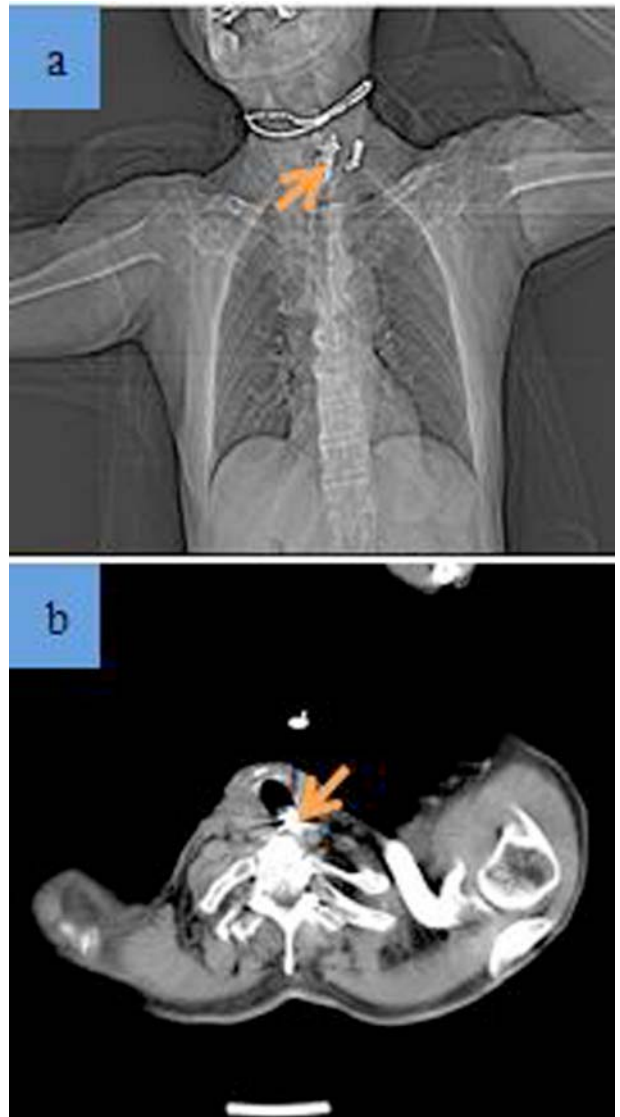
CT scans (a and b) demonstrated the dentures extending from C6 to C7.
